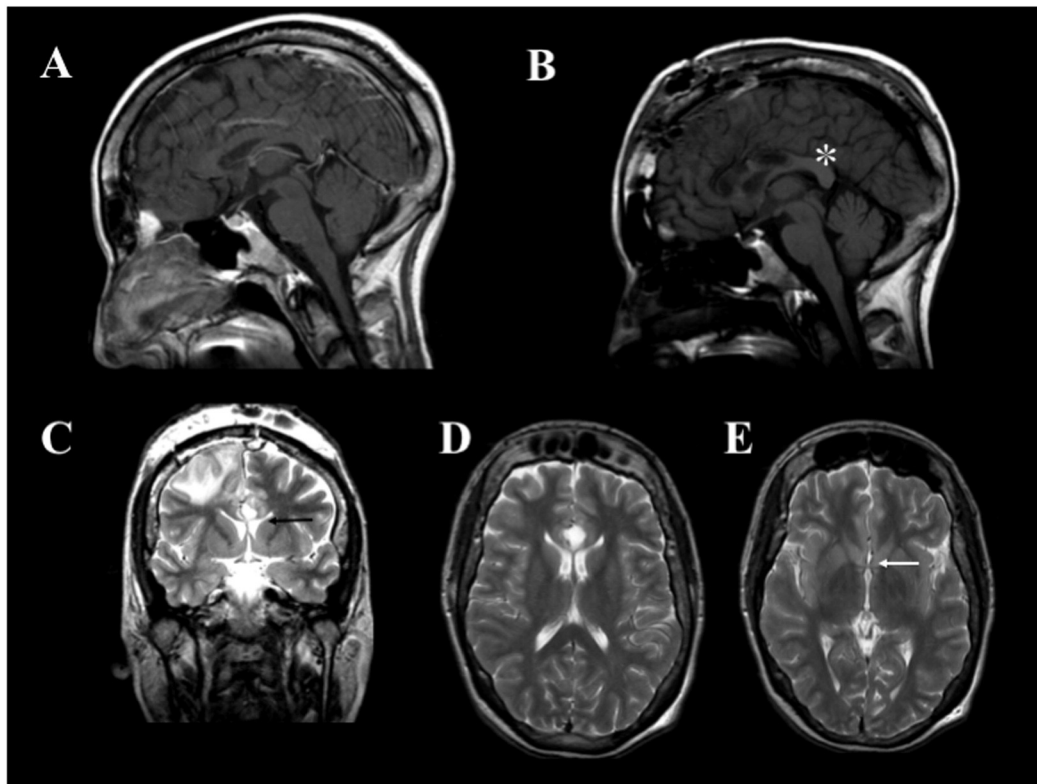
Preoperative and postoperative MRI images. A. Preoperative sagittal T1-weighted image showed the intact corpus callosum. B. Postoperative sagittal T1-weighted image demonstrated the anterior two-thirds callosotomy with preservation of the splenium (asterisk). C. Postoperative coronal T2-weighted image revealed the complete callosotomy without ependymal damage (black arrow). D. Postoperative axial T2-weighted image showed the anterior extension of the callosotomy up to the genu. E. Postoperative axial T2-weighted image showed the preservation of the anterior commissure (white arrow).
